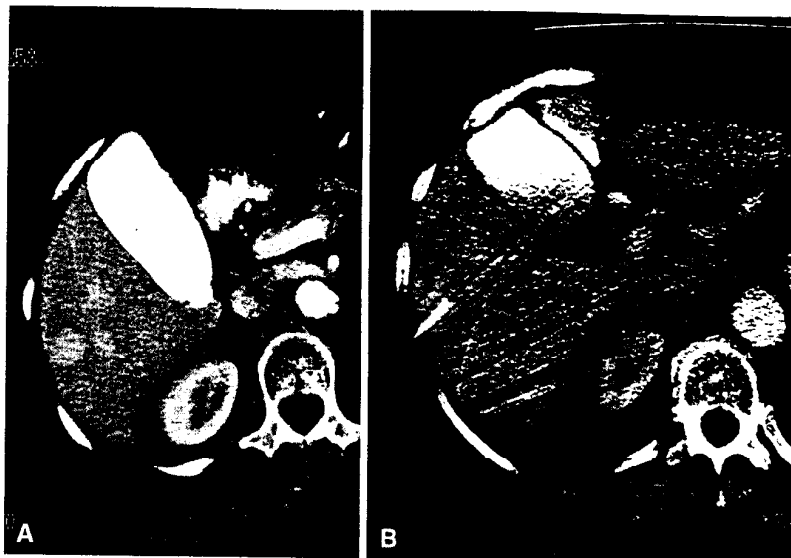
A Axial CT image from arterial-phase helical CT scan in a 72-year-old woman demonstrates multiple small enhancing lesions within the right lobe of the liver. Lesions were not visible on noncontrast-enhanced or portal venous contrast-enhanced scans. Contrast within the gallbladder is from a recent endoscopic retrograde cholangiopancreatograph. B Reconstructed image "frame" from real-time CTF biopsy during hepatic arterial phase of contrast enhancement demonstrates the tip of the biopsy needle after advancement to the periphery of a transiently enhancing hepatic lesion. The procedure was performed with the patient in the prone position, but the image has been rotated. This lesion was targeted because of its size and location. Note the close proximity of the lung to the biopsy path.
